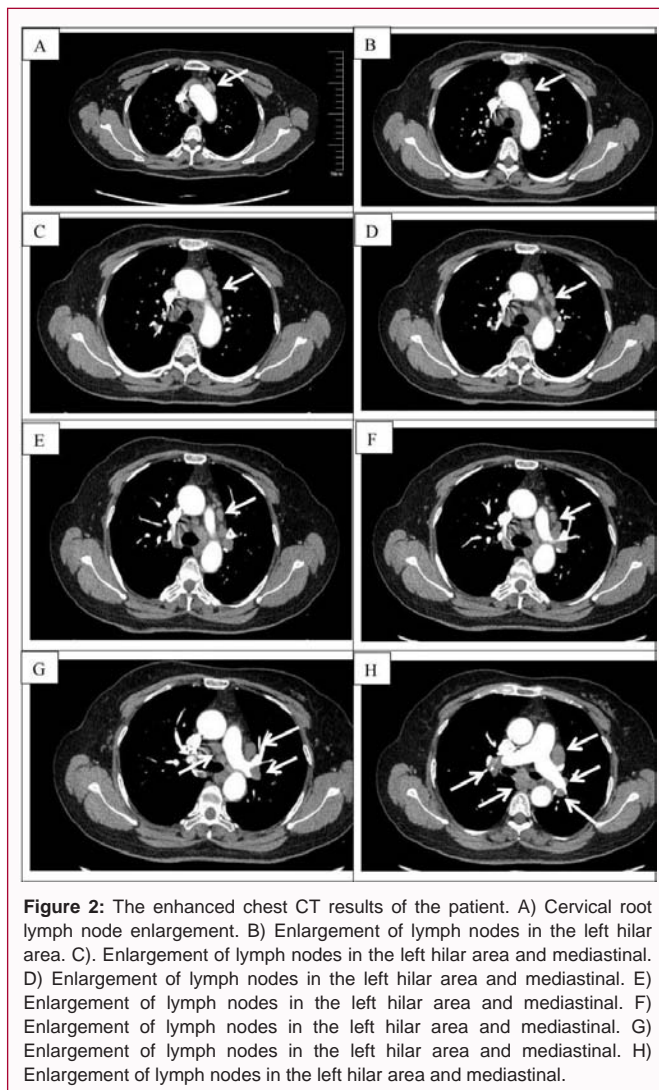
The enhanced chest CT results of the patient. A) Cervical root lymph node enlargement. B) Enlargement of lymph nodes in the left hilar area. C) Enlargement of lymph nodes in the left hilar area and mediastinal. D) Enlargement of lymph nodes in the left hilar area and mediastinal. E) Enlargement of lymph nodes in the left hilar area and mediastinal. F) Enlargement of lymph nodes in the left hilar area and mediastinal. G) Enlargement of lymph nodes in the left hilar area and mediastinal. H) Enlargement of lymph nodes in the left hilar area and mediastinal.
